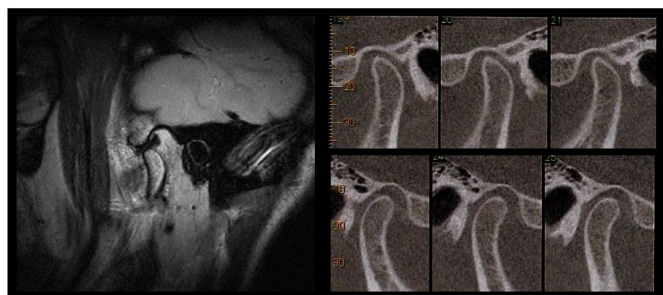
Magnetic Resonance Imaging (MRI) and Cone Beam Computed Tomography (CBCT)
